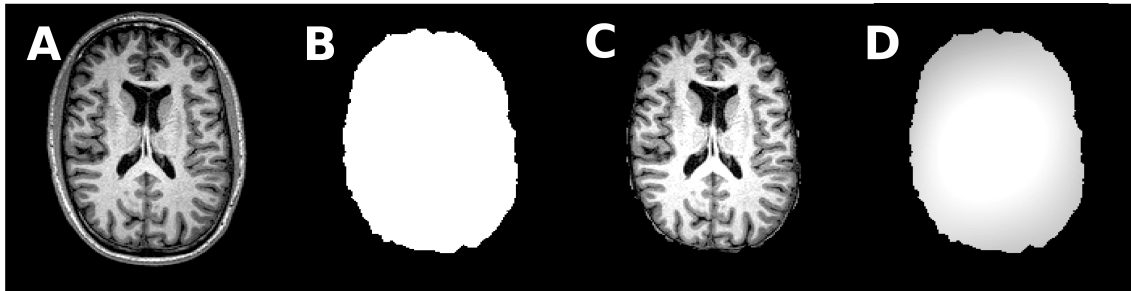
MRI pre-processing steps. A) T1-w image sequence. B) Computed brain mask using the BET approach [66] and C) skull stripped T1-w sequence. D) Estimated T1-w bias-field using the N3 method proposed by [65].
